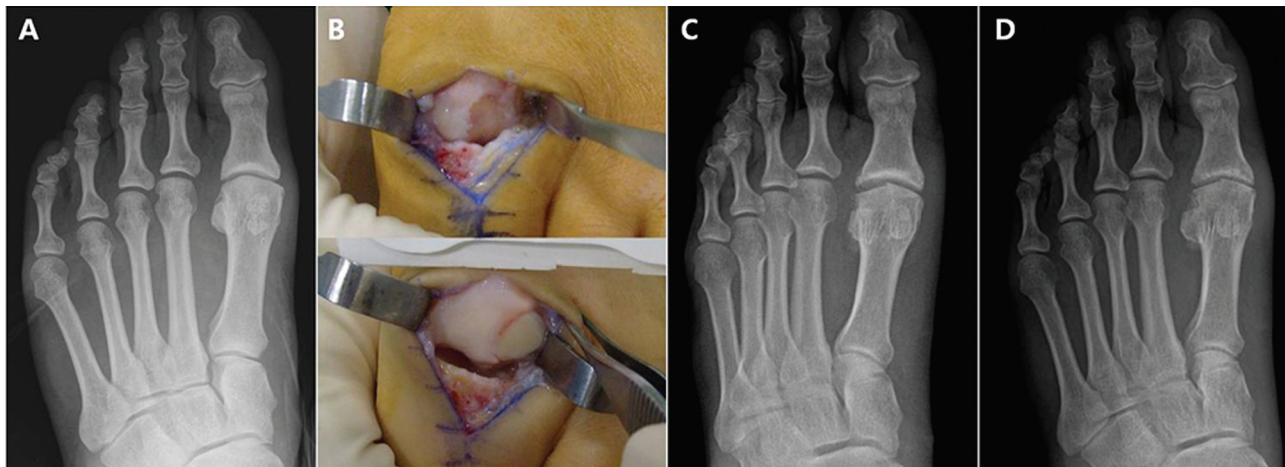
(A) Preoperative anteroposterior radiograph of the left foot. (B) Intraoperative photographs. The 10-mm-diameter plug was grafted to the defect area. (C) Postoperative anteroposterior radiograph of the left foot. Uneven radiographic appearance of the subchondral bone was observed. (D) Anteroposterior radiograph of the left foot at 18 months after the operation. No interval change was found compared with the postoperative radiograph.
